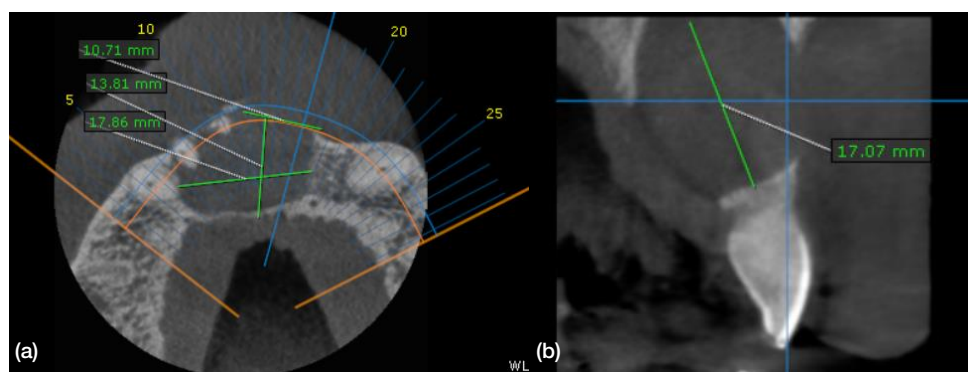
CBCT images – (a) transversal section (b) sagittal section
